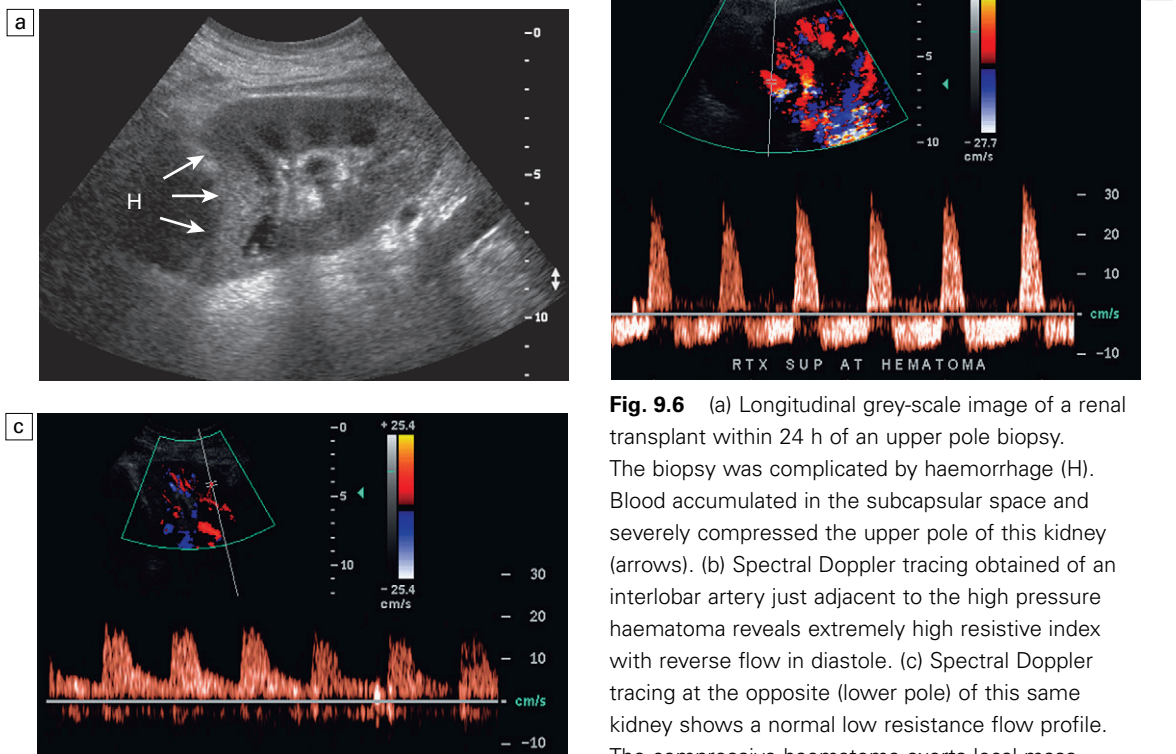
(a) Longitudinal grey-scale image of a renal transplant within 24 h of an upper pole biopsy. The biopsy was complicated by haemorrhage (H). Blood accumulated in the subcapsular space and severely compressed the upper pole of this kidney (arrows). (b) Spectral Doppler tracing obtained of an interlobar artery just adjacent to the high pressure haematoma reveals extremely high resistive index with reverse flow in diastole. (c) Spectral Doppler tracing at the opposite (lower pole) of this same kidney shows a normal low resistance flow profile. The compressive haematoma exerts local mass effect and elevates resistance to flow.
